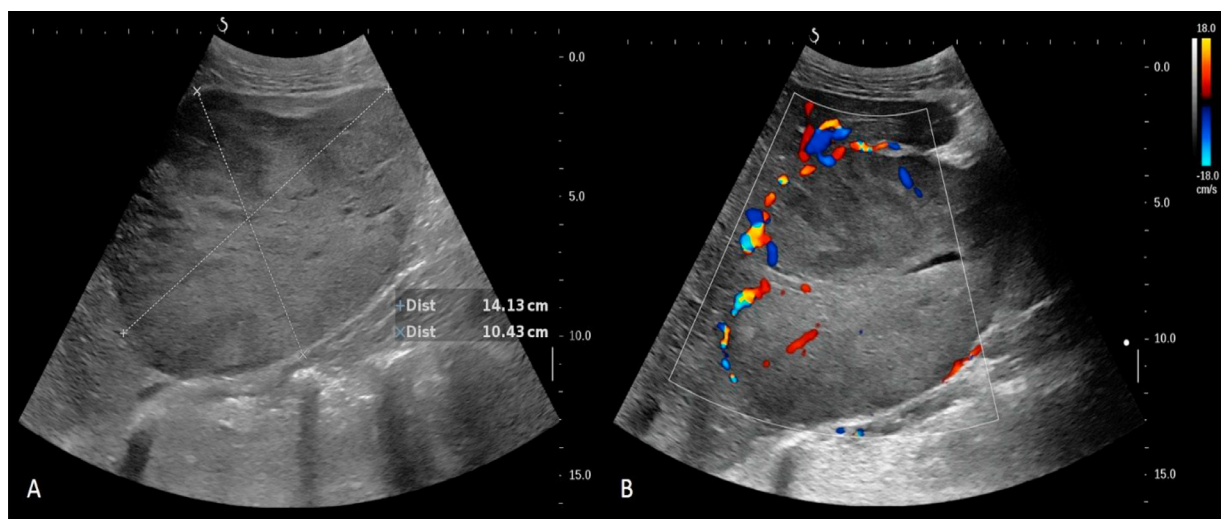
Hepatic Epithelioid Hemangioendothelioma: ultrasound showing (A) large heterogeneously hypoechoic space occupying lesion in the liver, (B) on color Doppler, flow signals are seen predominantly at the periphery of the lesion.
